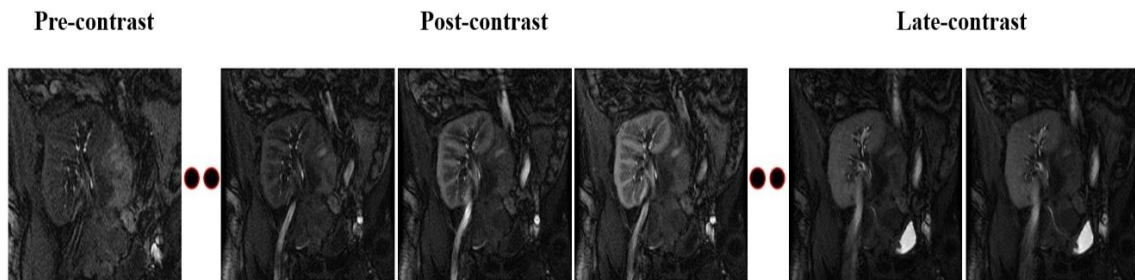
Example of an DCE-MRI sequence with Pre -, Post-, and Late- contrast images
